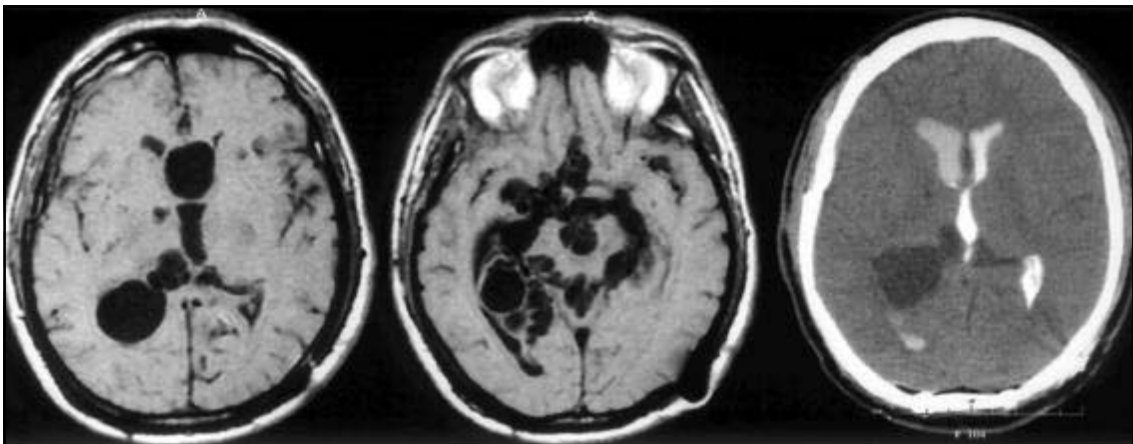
MRI Axial T1WI and CT Cisternography: Racemous form in the basal cisterns with cyst within the ventricular atrium.
